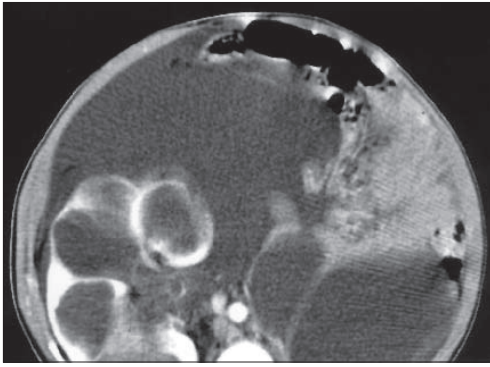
Enhanced CT scan showing cystic dysplastic left kidney and advanced right hydronephrosis.
